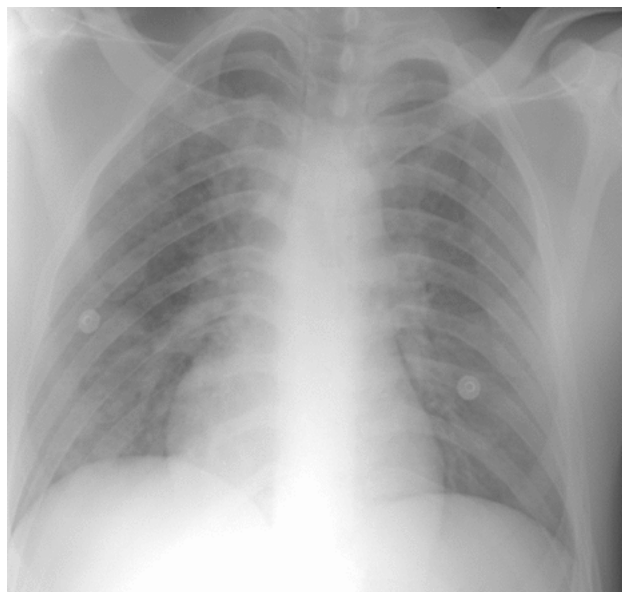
Initial chest radiograph with bilateral diffuse infiltrations
